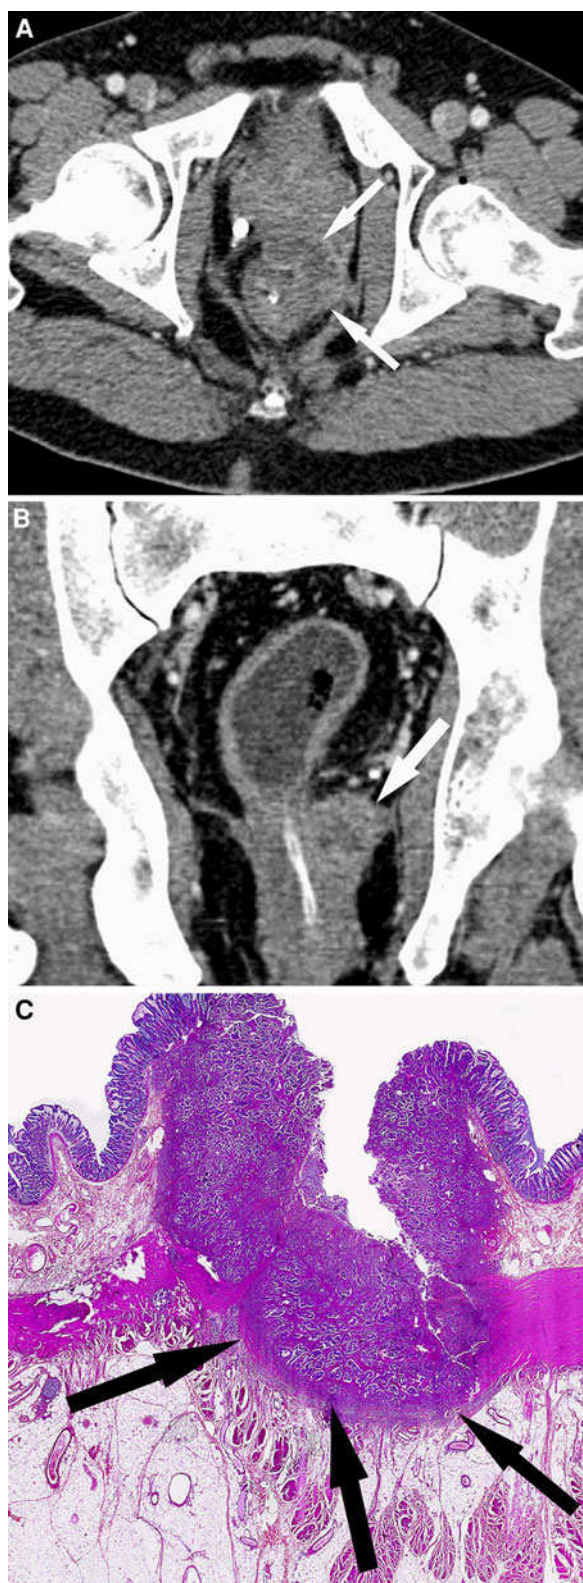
A 43-year-old man with ulcerative colitis known for 17 years presenting with colonic obstruction. Optical endoscopy (not shown) revealed complete stenosis of sigmoid colon due to tumor and findings consistent with active ulcerative colitis. A Helical CT obtained in the axial plane after intravenous administration of iodinated contrast material shows moderately enhancing tissue mass (*arrow*) of the sigmoid colon. Submucosal fat accumulation is visible (*arrowhead*). B Helical CT obtained in the coronal plane shows large, intraluminal soft tissue mass of the sigmoid colon (*arrow*) involving
